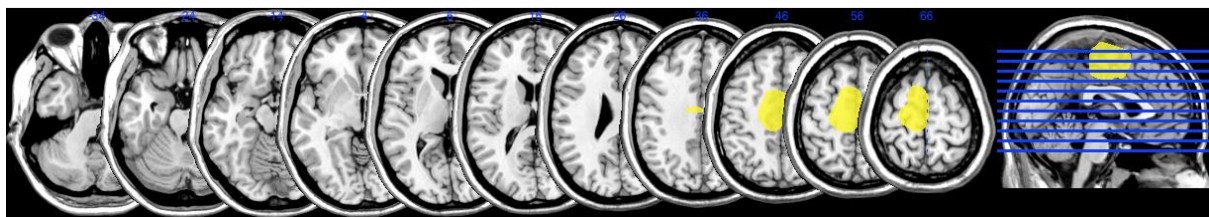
MRI scan of patient BD
